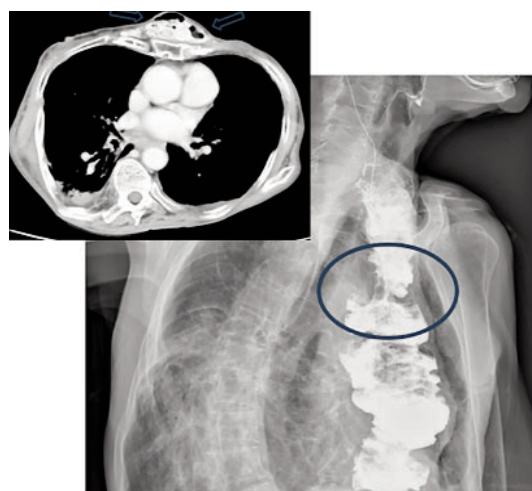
Barium swallow. Time of passage of the barium substance through the graft, highlighting an area of stenosis with a neoplasia-like appearance. In the inset, CT image, cross-section confirming the presence of a tumor formation with invasion of the entire parietal wall
